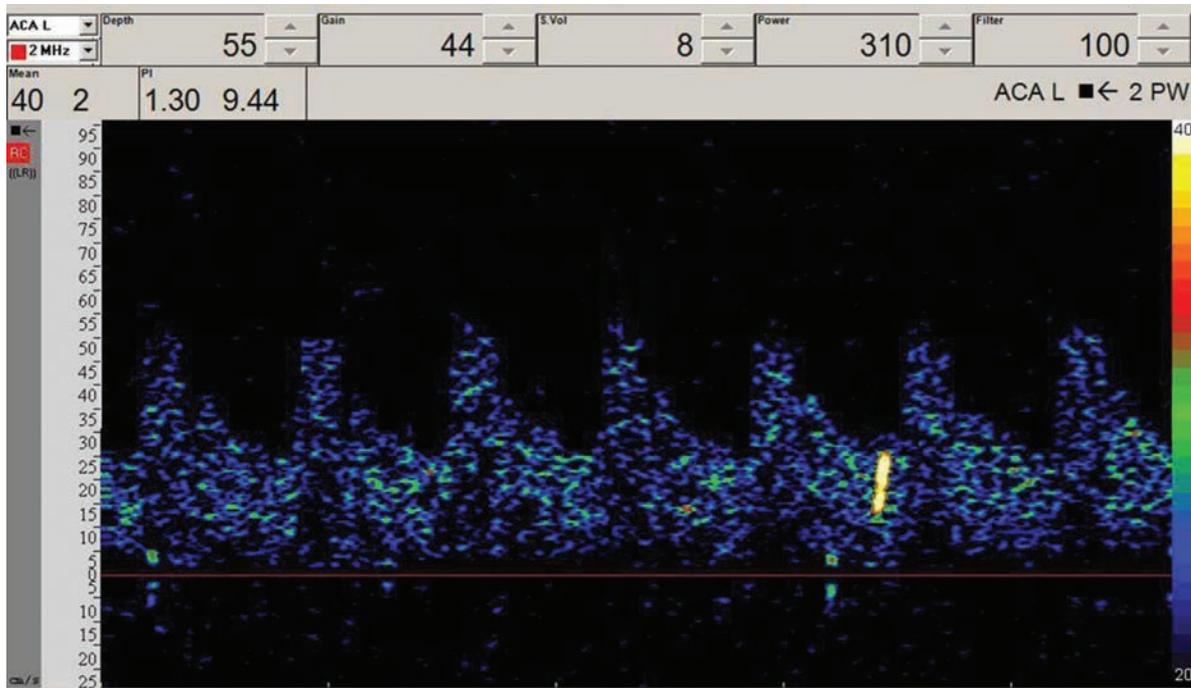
A microembolus signal visible on transcranial Doppler registration of anterior cerebral artery.
